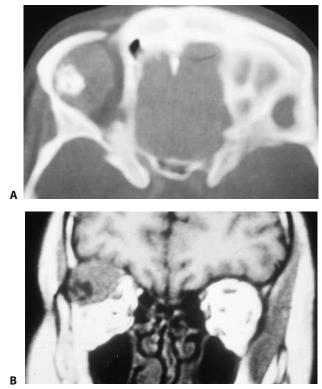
Adenoid cystic carcinoma of the lacrimal gland. (A) Coronal CT scan (bone window) showing the highly dense calcification within the tumor. (B) Axial T1-weighted image showing the calcified portion of the tumor as signal void.
